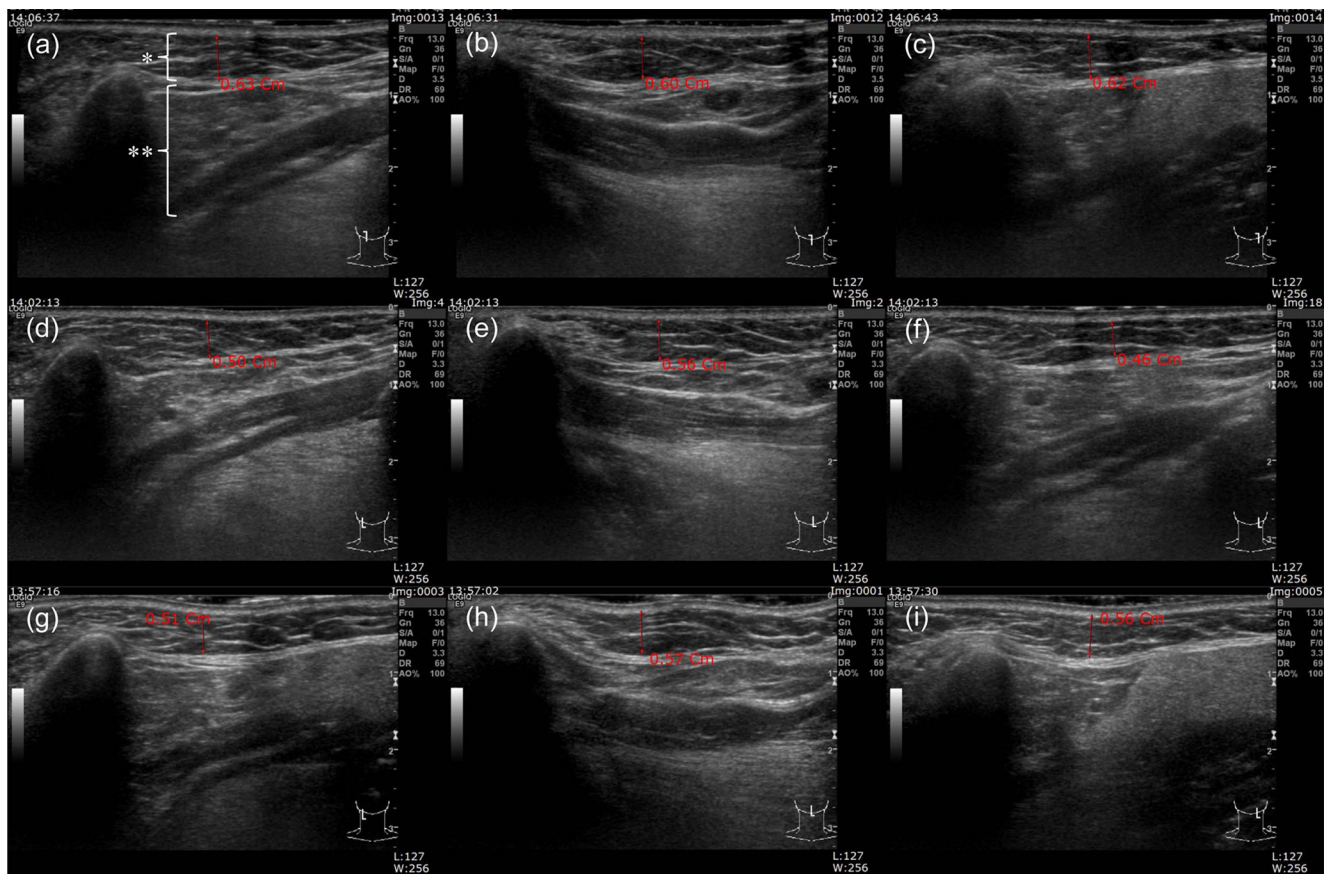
Ultrasound photography of the right-median (a, d, g), median (b, e, h), and left-median (c, f, i) submental area in a patient. a, b, c At pretreatment (baseline); d, e, f at 1 month after the last treatment; g, h, i at 6 months after the last treatment (asterisk, subcutaneous fat; double asterisk, muscle)
